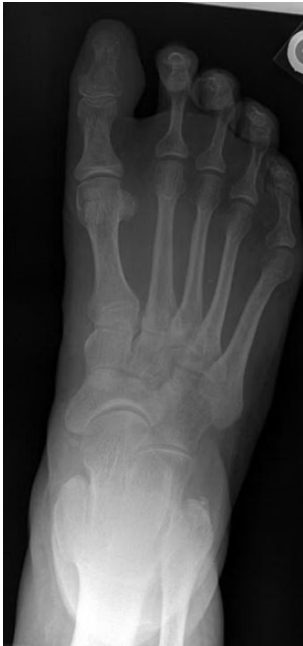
X-ray DP view right foot.
